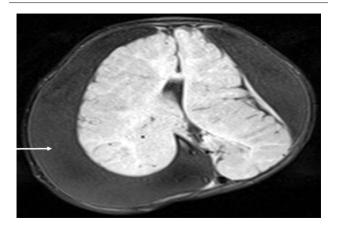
Axial FLAIR (Fluid Attenuated Inversion Recovery) image showing complete suppression of fluid collection (indicated by the white arrow), confirming it as cerebrospinal fluid (CSF).
